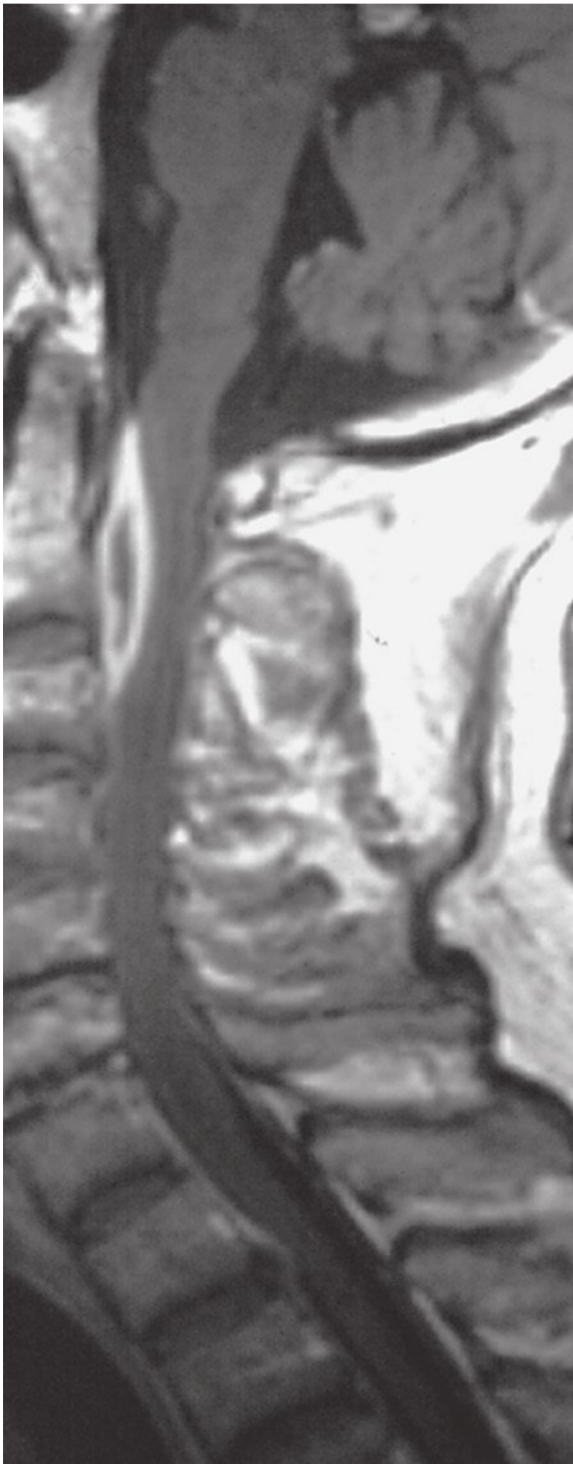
Sagittal T2-weighted magnetic resonance imaging of a subdural abscess versus epidural metastases in the cervical spine. (From Uhlenbrock D. *MR Imaging of the Spine and Spinal Cord*. Stuttgart, Germany: Georg Thieme Verlag; 2004: Fig. 6.50. Reproduced with permission.)
